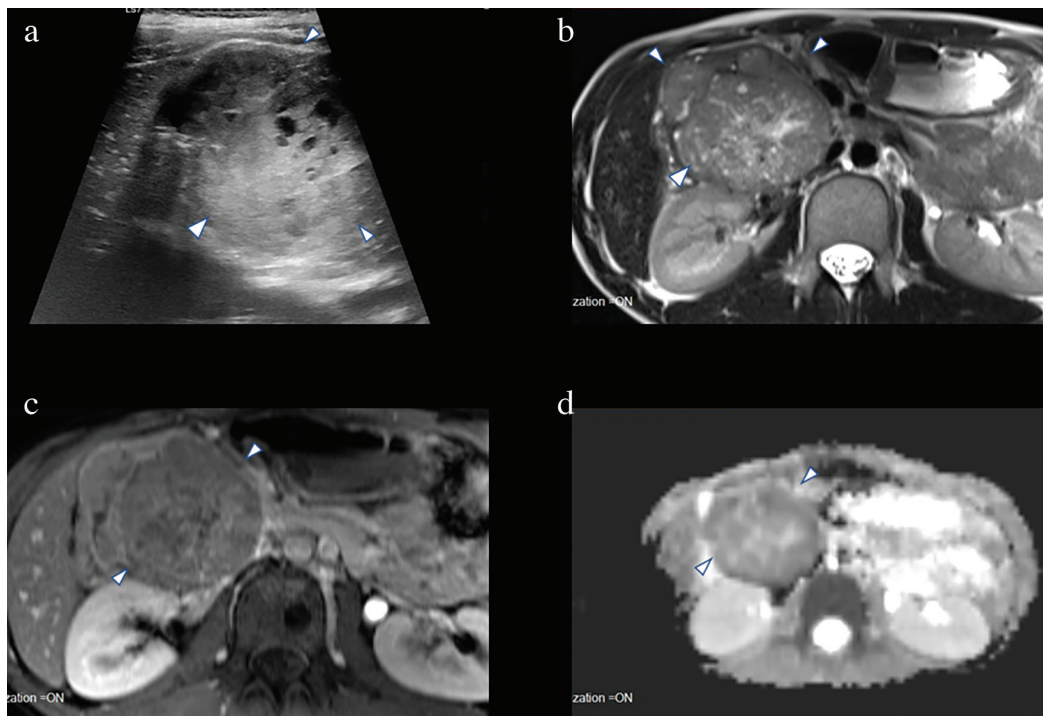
Pancreatoblastoma of the pancreatic head-uncinate process in a 15-year-old male. (a) USG demonstrates a 61 × 51 mm well-defined solid mass with lobulated superior-lateral contour, millimetric internal cysts, and inferior vena cava compression. (b) T2-WI-MRI reveals a large head-uncinate mass with internal microcystic foci and focal necrosis. (c) Late-phase contrast-enhanced MRI demonstrates heterogeneous enhancement. (d) DWI shows diffusion restriction within the lesion.
